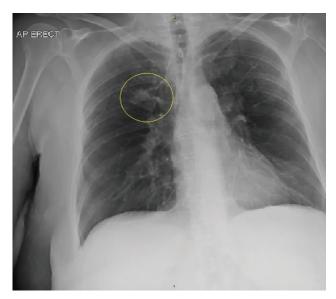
Chest radiograph on day 4 showing interval improvement in opacity superior to the right hilum (circle).
